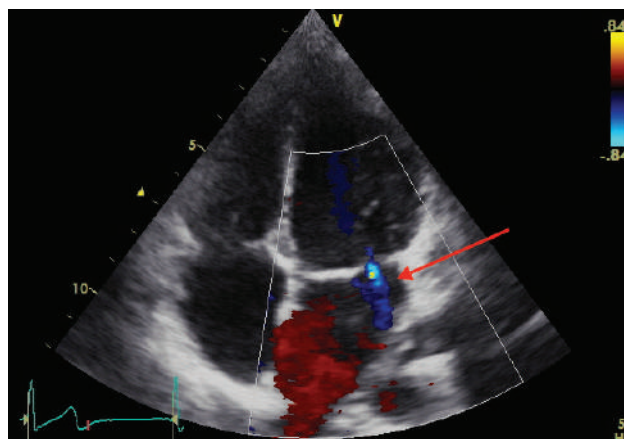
Rheumatic mitral valve; mitral regurgitant jet needs to measure at least 2 cm on colour Doppler (if patient weighs over 30 kg) to meet RHD diagnostic criteria for pathological regurgitation (red arrow). (See Table 8.6)
